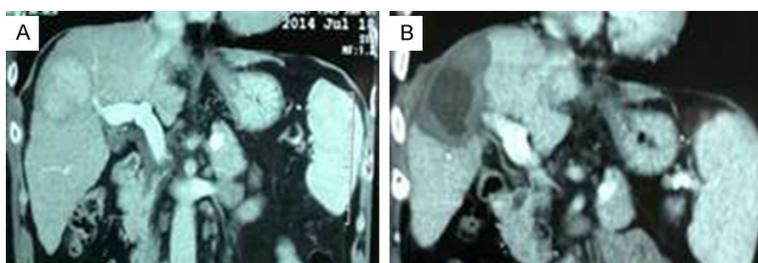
A. Contrast CT scan shown tumor in right liver preoperatively. B. A contrast CT scan shown necrotic area in resection margin of liver parenchyma 1 year postoperatively.
